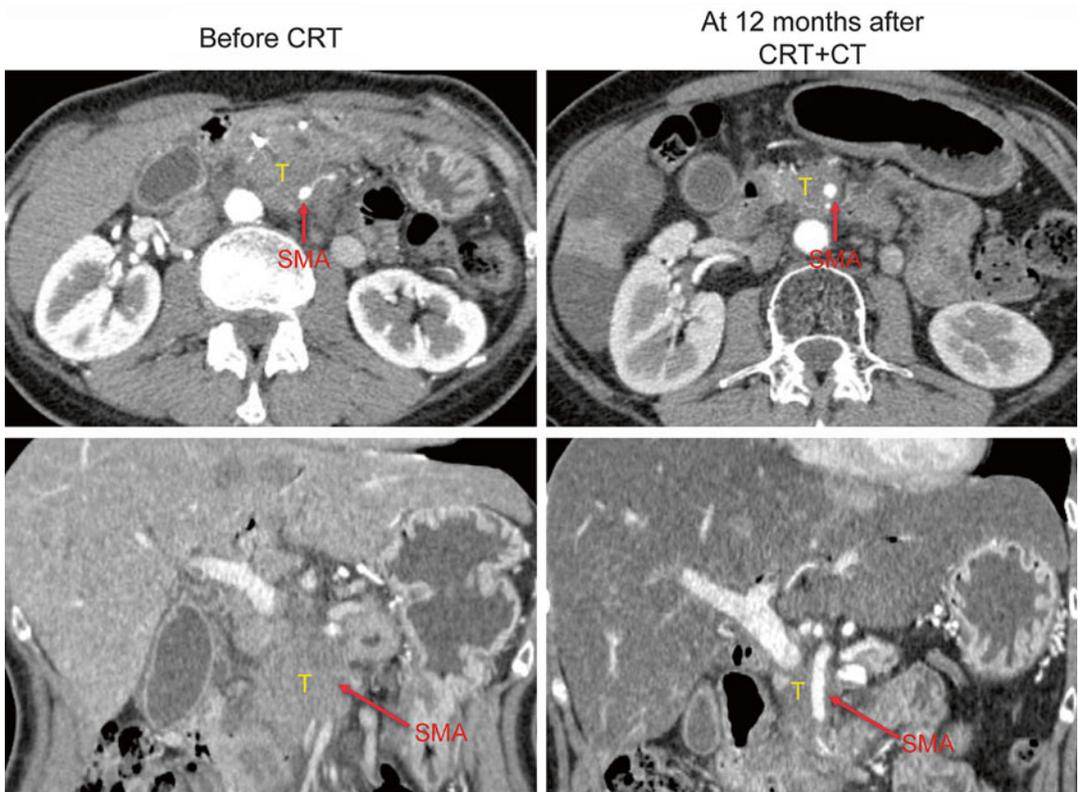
CT images of a 54-year-old female with LUR-PDAC before CRT and at 12 months after the beginning of CRT followed by chemotherapy. Before CRT, the tumor abutted the SMA nearly 360° of its circumference (cross section image) and the SMA was poorly visualized (coronal image). At 12 months after the beginning of CRT
